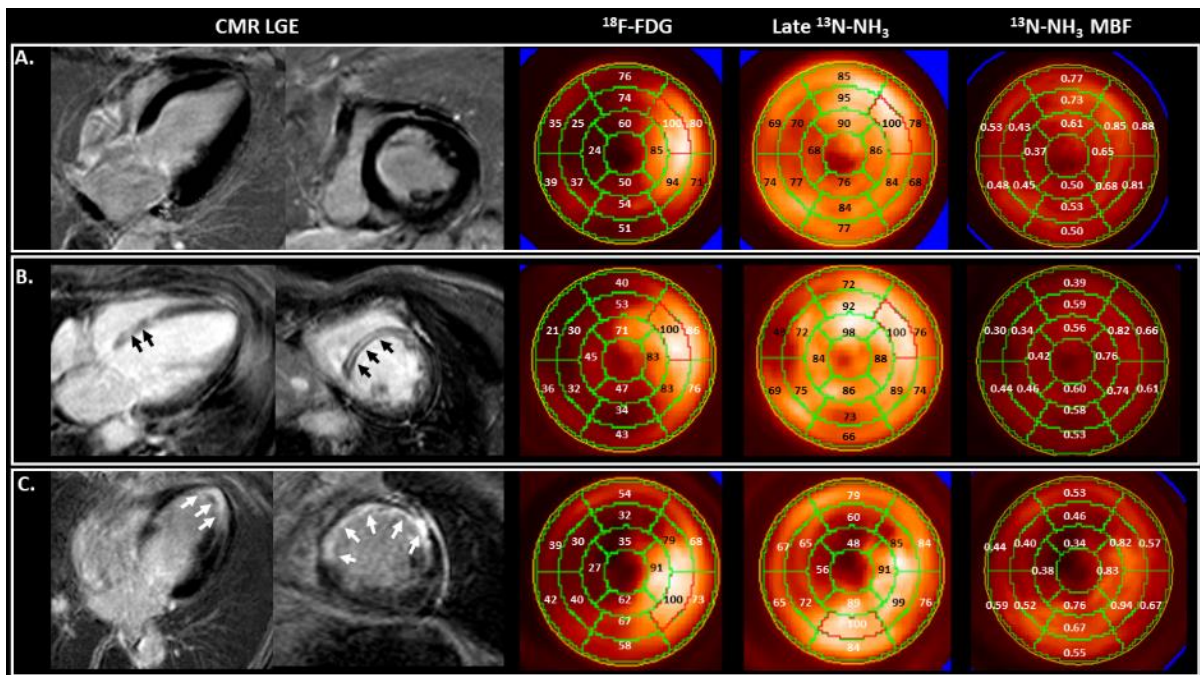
Representative examples of ^{18}F -FDG, late ^{13}N -NH $_3$ and ^{13}N -NH $_3$ -derived absolute MBF polar maps in LBBB patients without myocardial scar (A), with non-transmural myocardial scar (B) and with transmural myocardial scar (C) on late-gadolinium enhancement CMR. Values on the ^{18}F -FDG and late ^{13}N -NH $_3$ polar maps are represented as percentage of the segment with the highest mean tracer uptake. Values on ^{13}N -NH $_3$ MBF polar map are expressed as ml/min/g tissue.
